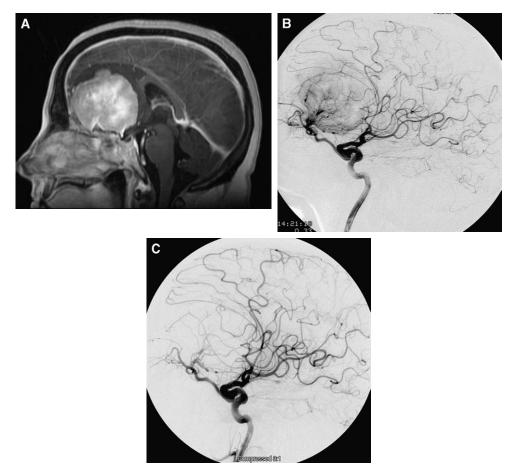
(A) Sagittal MRI shows a giant anterior skull base meningioma. (B) Lateral internal carotid artery angiographic injection shows the "sunburst" pattern of arterial supply. Ethmoidal branches arising from the ophthalmic artery feed this giant tumor. (C) The vascularity is markedly reduced after glue embolization.
